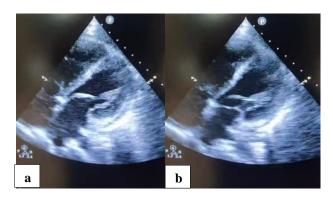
Echocardiogram on day 5 of admission in (a) diastole and (b) systole.
